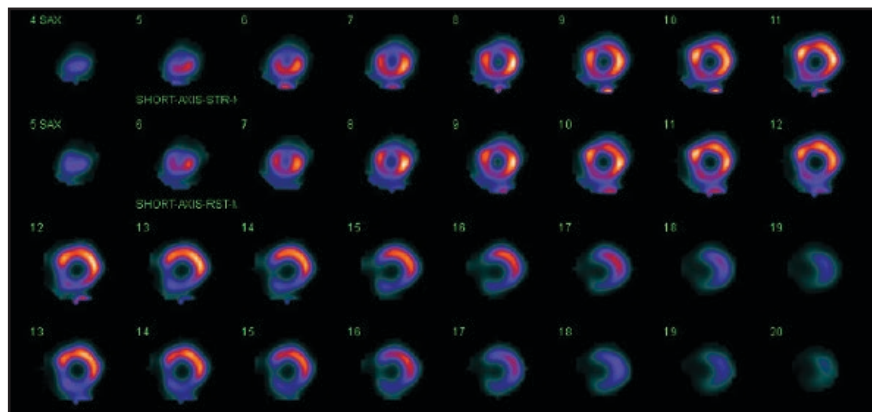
SA images from SPECT MPI show a small moderate distal anterior stress perfusion defect that is centrally fixed with reversibility along the margins, suggesting infarct with peri-infarct ischemia.
